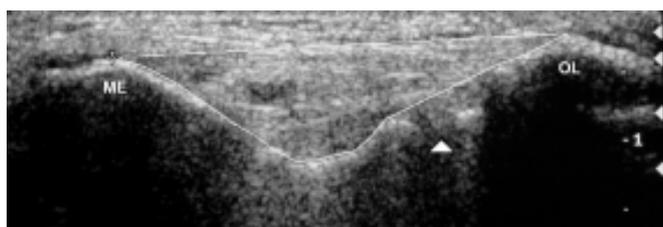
CT area (cm<sup>2</sup>). Electronic calipers are used to trace the area of the proximal osseous cubital tunnel. Note the measurement is continuous over the articulation of the trochlea and olecranon (arrowhead)
